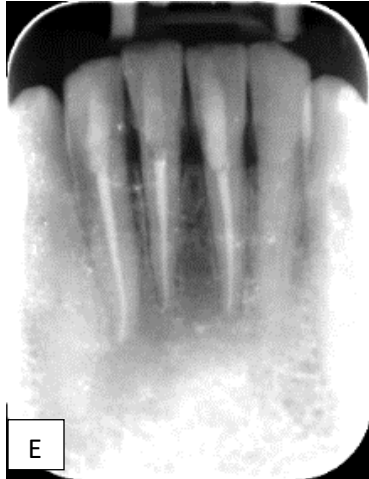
Periapical radiography demonstrating:
